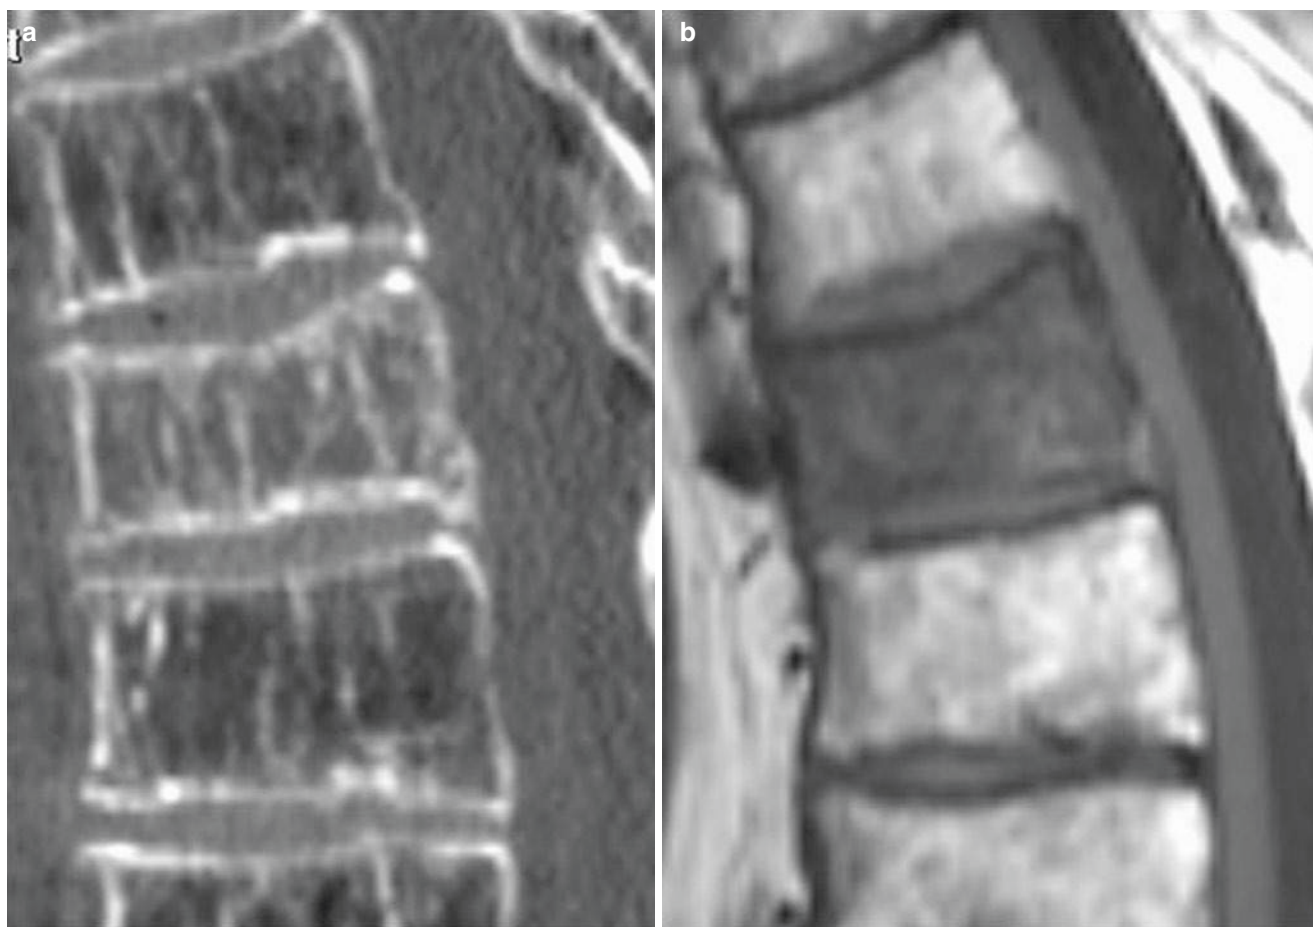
Osteoporosis and vertebral fracture. (a) A sagittal CT reformat of the thoracic spine shows reduced trabecular bone density and a vertebral fracture. (b) The corresponding sagittal T1-w SE image shows
